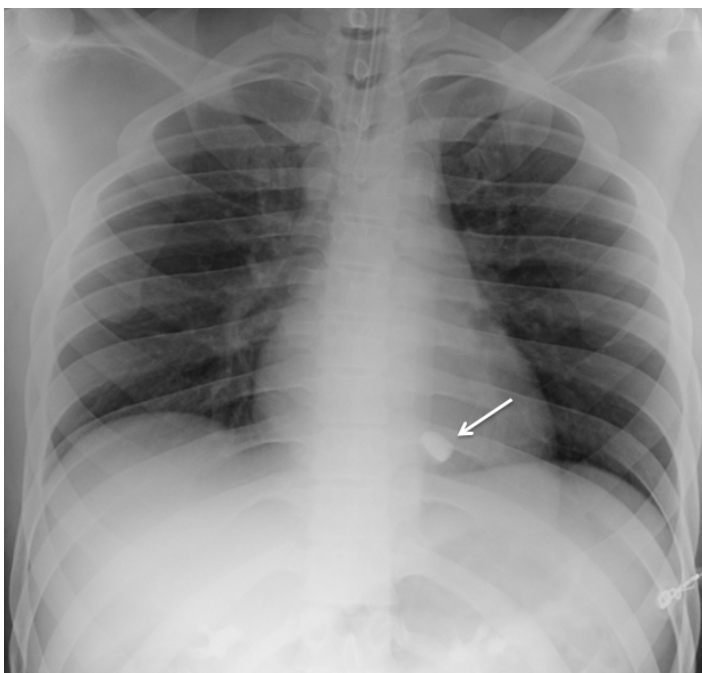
Chest radiograph showing blurred foreign body within the cardiac silhouette (arrow).
